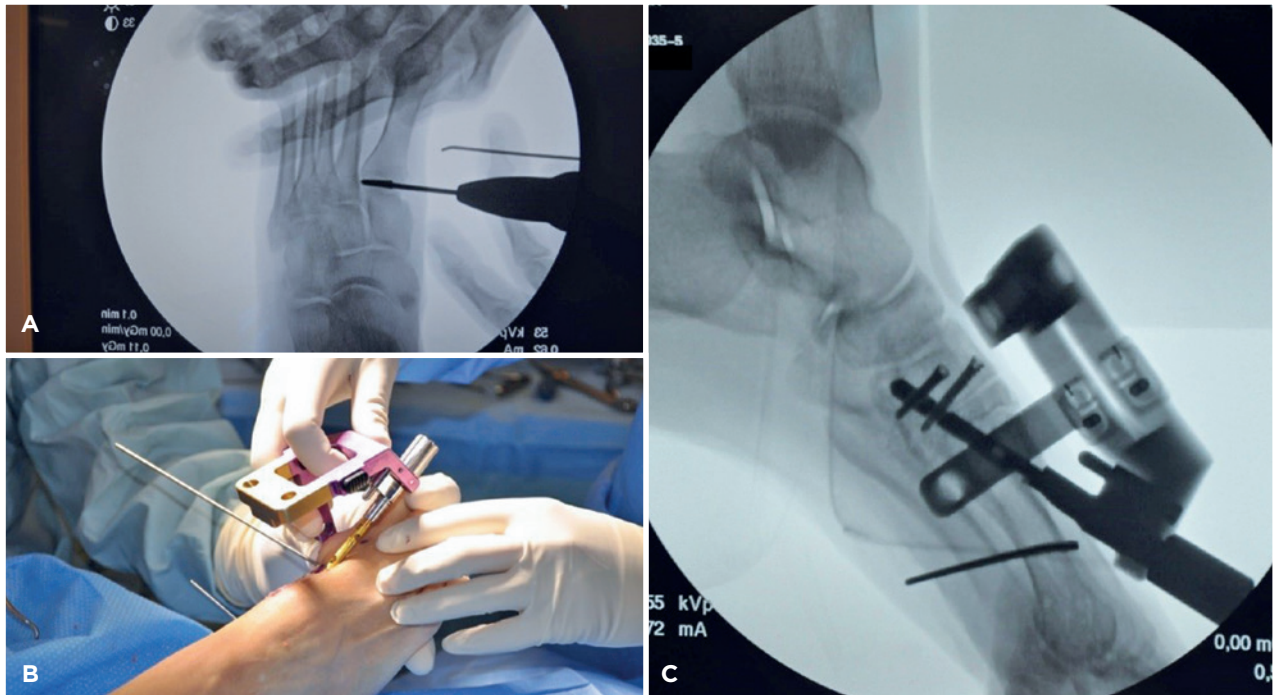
A. First TMT joint preparation through percutaneous approach with a Shannon burr. B. Clinical appearance during nail insertion. C. Sagittal radiographic appearance after nail insertion and proximal blocking screws.
